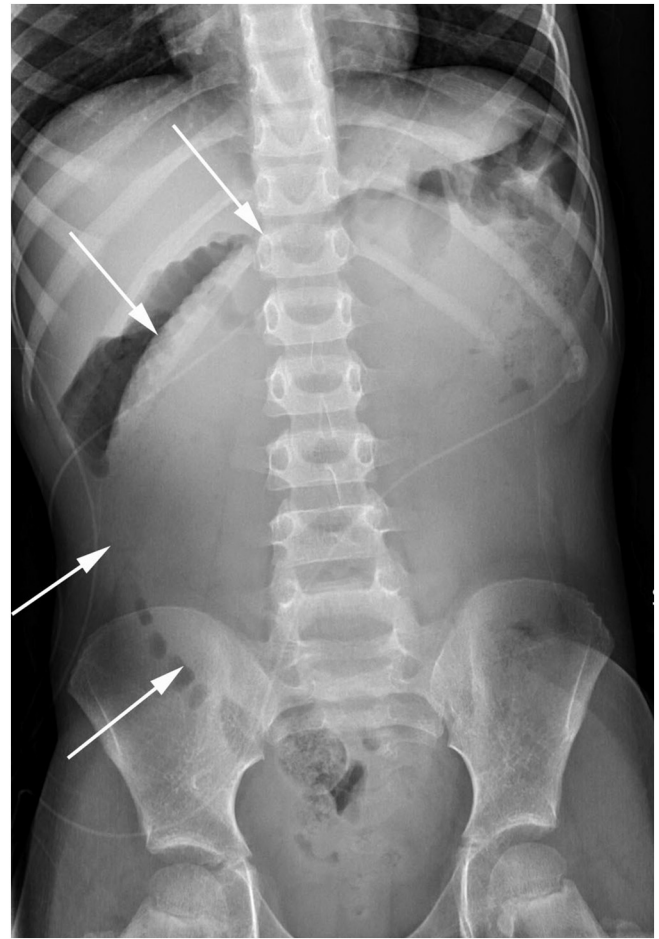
Supine abdominal radiograph demonstrates an overall paucity of bowel gas and a large dense structure in the central abdomen (arrows) exerting mass effect and displacing the ascending and transverse colon segments laterally and superiorly, respectively.
